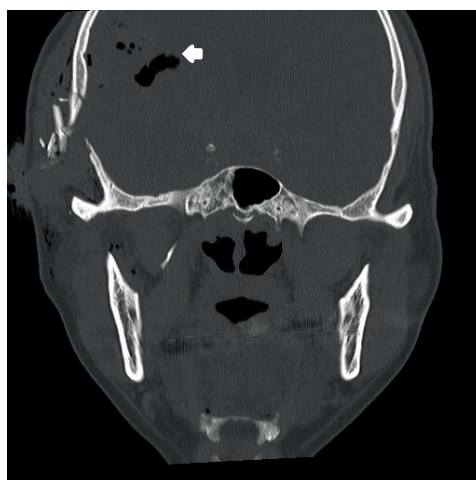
Coronal bone setting computed tomography image of the patient's head. Multiple open facial bone fractures and soft tissue edema including subcutaneous emphysema were diagnosed (white arrow: pneumocephalus).
